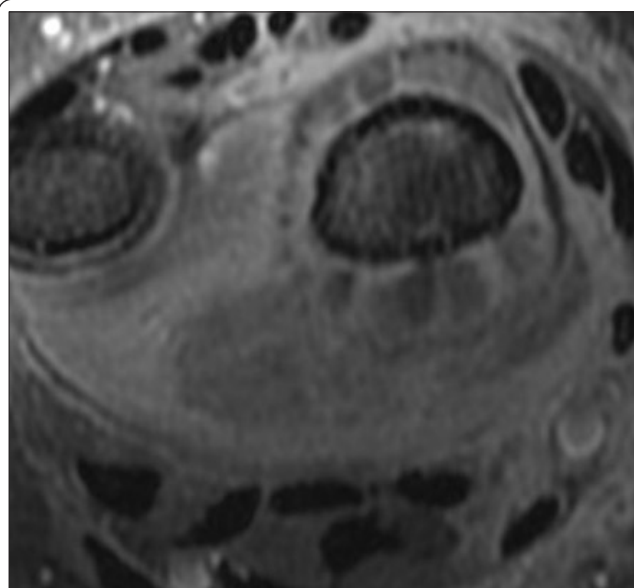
Post-contrast T1 MRI showed hypointense foci within the soft tissue mass, likely consistent with necrosis.
